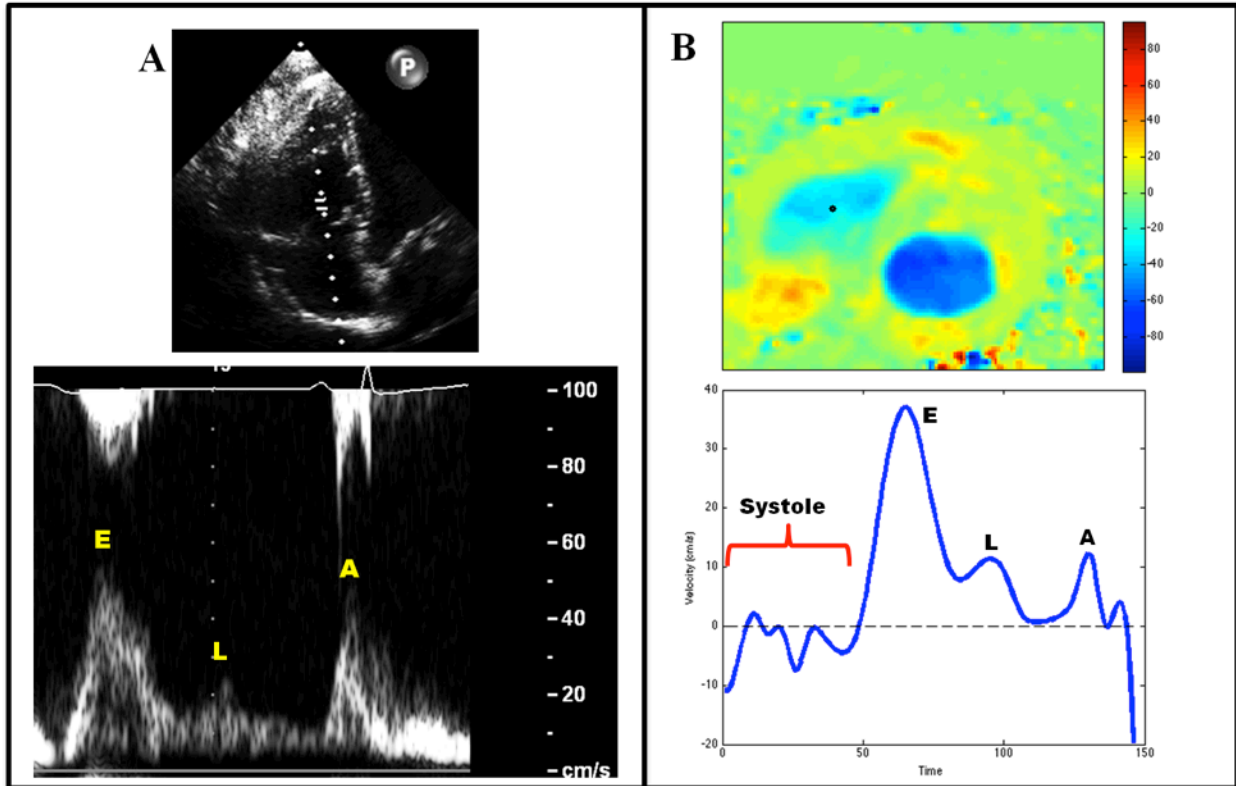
RV trans-tricuspid flow measured using 2D Doppler (A) and PC-MRI (B). (A) 2-D image showing sample volume location (upper panel) with Trans-tricuspid flow using 2D Doppler shows L-wave in the RV (lower panel). (B) Phase contrast cardiac short axis image (upper panel) at just below tricuspid annulus converted to (through-plane) velocity map. Color bar shows velocity in cm/s. Blue-green (negative) velocities indicate flow towards the apex. Lower panel: Through-plane velocity at selected fixed spatial location (black dot in center of tricuspid inflow track) for one cardiac cycle. Note presence of L-wave. See text for details. The pioneering work of Keren et al first described Doppler echocardiographic L-waves¹. It was
